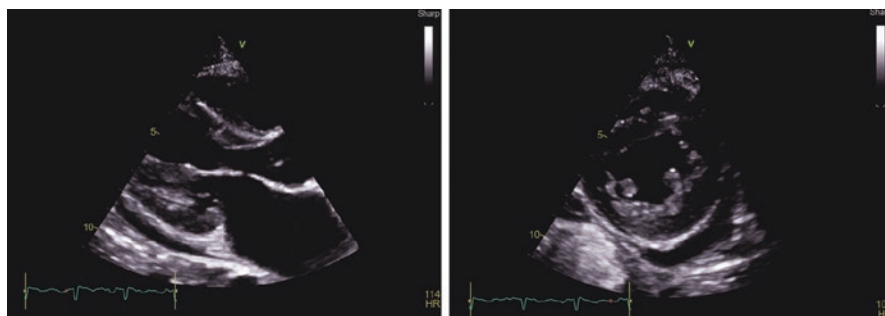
Echocardiography of the patient with pericardial effusion
